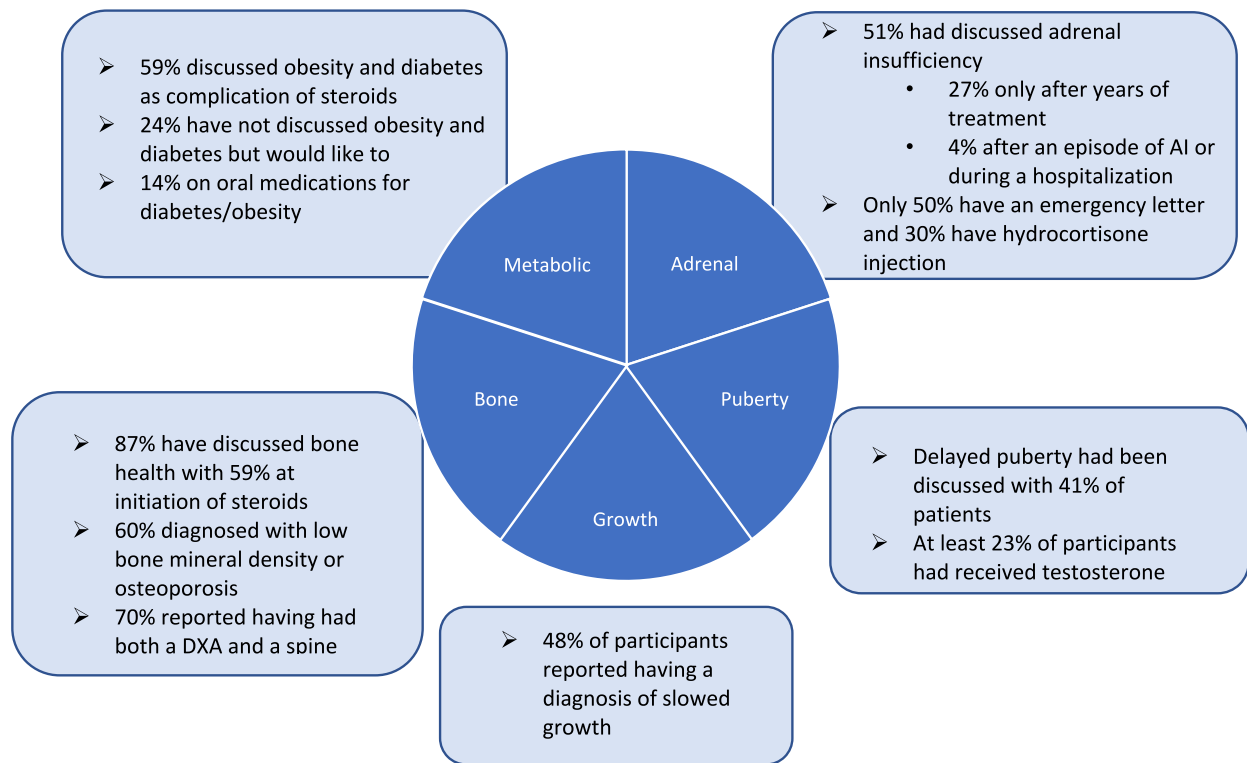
Main results, per endocrine system. DM: Diabetes Mellitus, AI: Adrenal insufficiency, DXA: Dual-energy X-ray absorptiometry.
